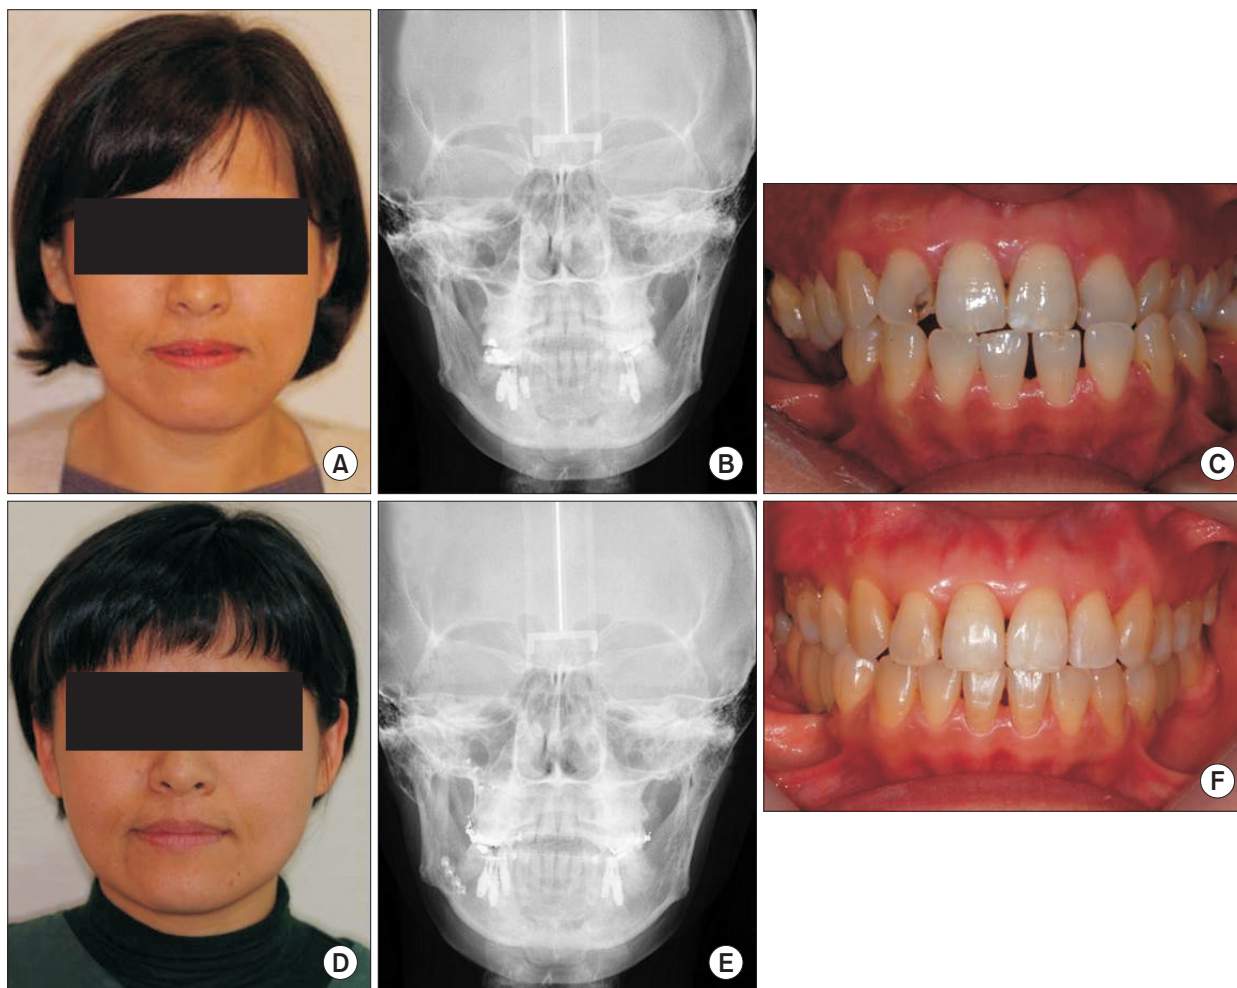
Clinical photography and radiography of case 3. A-C. The patient shows asymmetric mandibular prognathism, left unilateral cross-bite, loss of multiple bilateral lower posterior teeth, and extrusion of opposing teeth. D-F. Postoperative orthodontic treatment after right unilateral sagittal split ramus osteotomy (6-mm setback) and unilateral posterior maxillary segmental osteotomy, the patient obtained symmetrical facial morphology and balanced occlusion.
